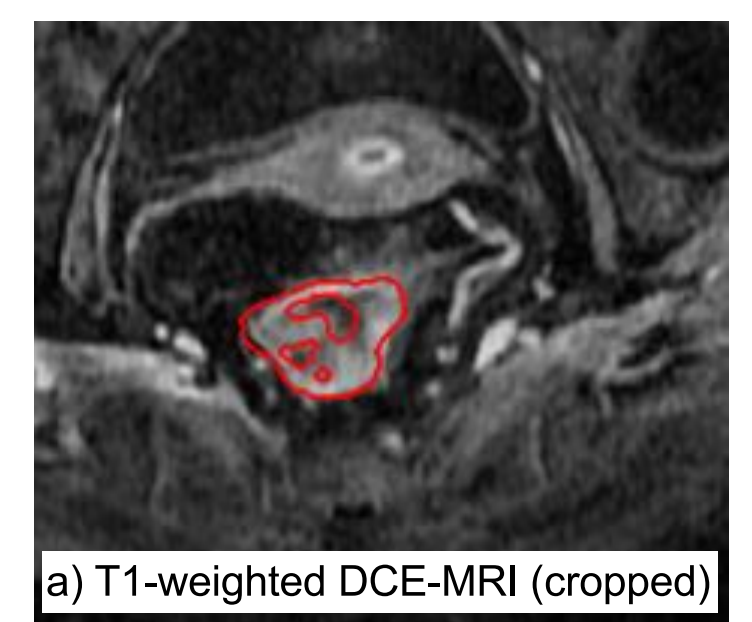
Colorectal MRI images with annotations a) DCE-MRI axial slice (with tumour annotation) b,c) Corresponding T2 MRI showing the inter-rater variability of the delineation
